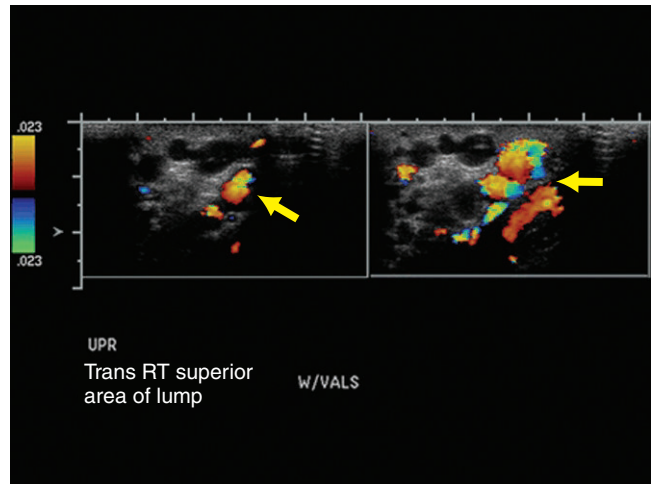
Transverse ultrasound with color Doppler upright and with valsalva (side by side, respectively) confirms that the hypoechoic serpiginous structures are indeed vessels and increase in caliber with valsalva maneuver (arrow). This is characteristic for varicocele.
